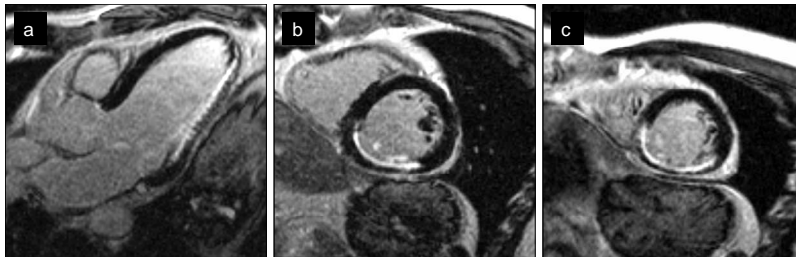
Four-chamber (a) and short axis (b) view acquired with dark-blood, T2-weighted spinecho imaging with fat-suppression in a patient with 5-day old reperfused anteroseptal myocardial infarction.
